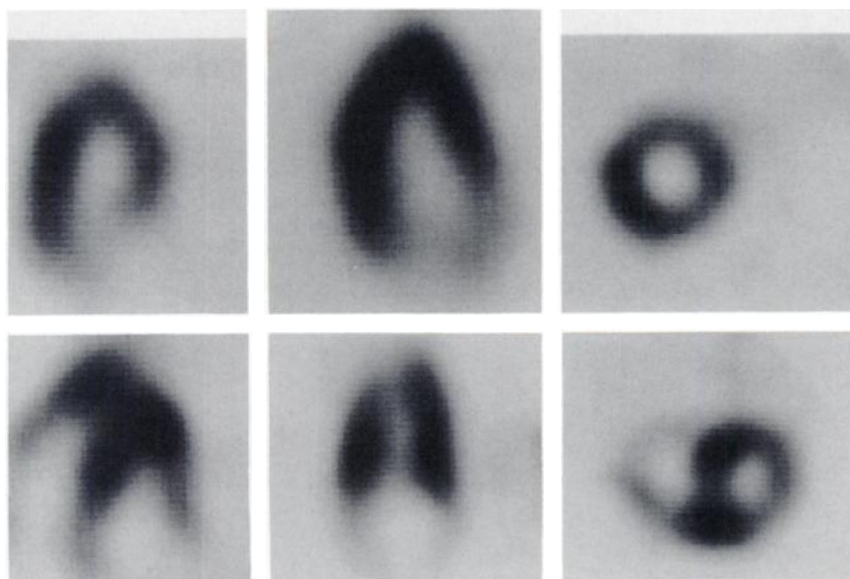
Clinical study—horizontal motion. Shown are examples of SPECT short-axis (left column) vertical long axis (center column) and horizontal long-axis (right column) slices acquired postexercise in a clinical study associated with obvious horizontal displacement (above). Gross artifactual duplication of shifted ventricular walls is apparent in short-axis and horizontal long-axis slices. These could not be software corrected but were no longer evident on subsequent re-study (below). Rotation in or counter to the orbital direction was evaluated in computer studies. However, in this clinical case there was evident horizontal motion in addition to rotation.
